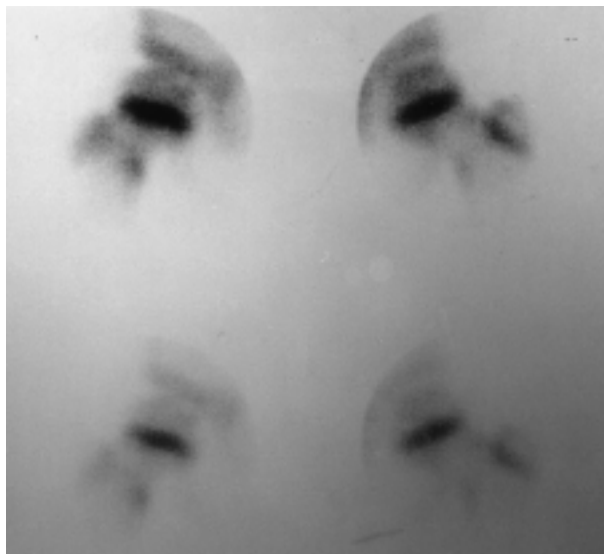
Bone scintigraphy performed 3 months after diagnosis.
